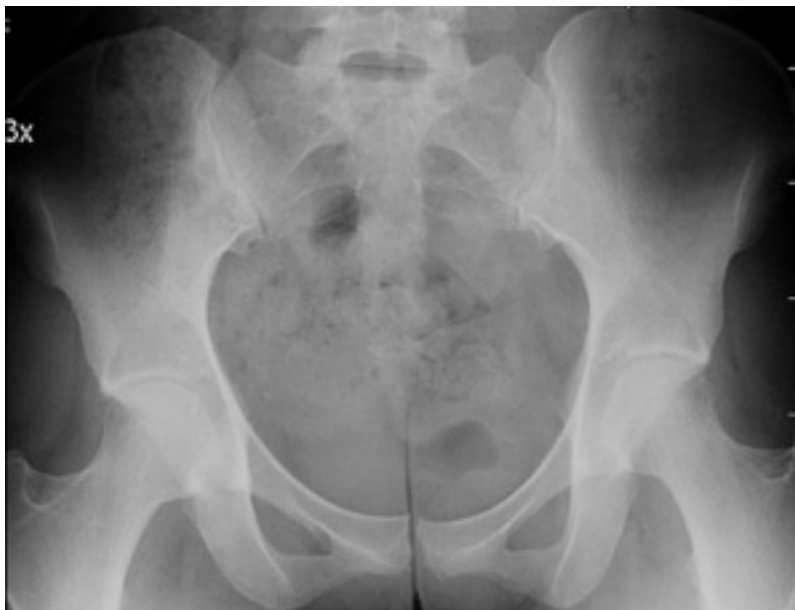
Anteroposterior radiograph of the pelvis showing anterior rotation of the pelvis and coxa profunda. Borderline appearance of acetabular retroversion needs to be interpreted with caution in setting of pelvis anterior rotation.
